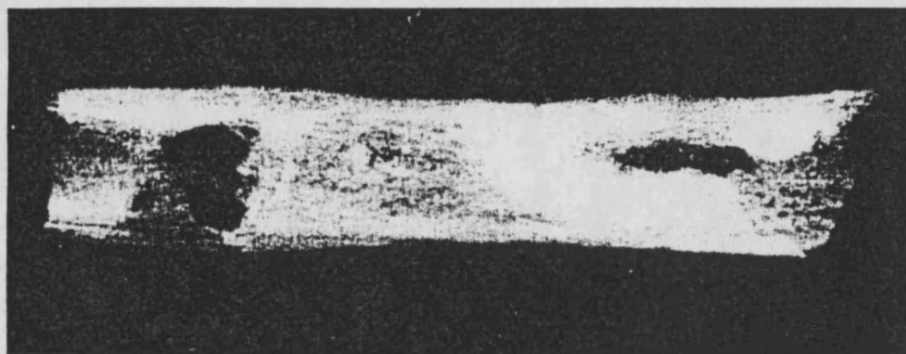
X-ray of sample 5.
